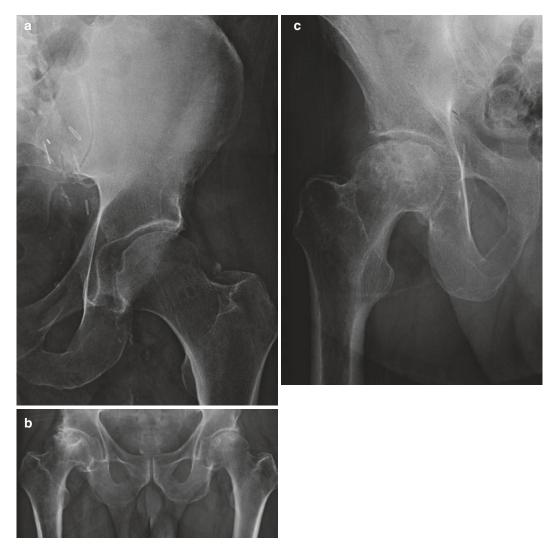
(a) Modified AP radiograph of the left hemi-pelvis, surgical clips related to renal transplant, left hip pain, generalized osteopenia, no radiographic changes AVN, stage 1 AVN. (b) AVN of bilateral hips on AP radiograph, stage 4. The right hip demonstrates partial collapse of the femoral head and secondary degenerative changes, stage 2a; the left femoral head demonstrates localized sclerosis in a patient on longterm steroids. (c) AP radiograph of the right hip with stage 3 AVN, with collapse of the femoral head with maintenance of joint space. See Table 12.2 for detailed description of the staging of AVN loss of convexity or flattening indicates early collapse. Collapse progresses with deformity of the femoral head and development of secondary degenerative changes such as joint space loss, osteophytes, subchondral sclerosis, and cyst formation. These latter changes may be more evident on the acetabular aspect of the joint as the femoral head collapses. Radiographic findings are detailed in Table 12.2.
